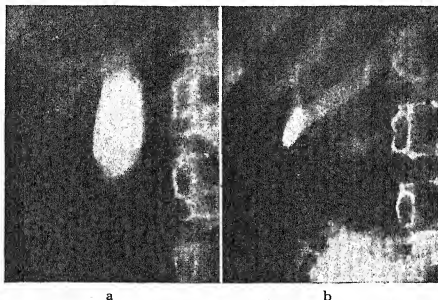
X-ray photographs of the gall-bladder of a man before (a) and twenty minutes after (b) a meal of fat, the gall bladder has been intravenously injected with dye (Graham-Cole test) fourteen hours before. Fat in the duodenum causes the gall bladder to empty. (Winton and Bayliss "Human Physiology.")
